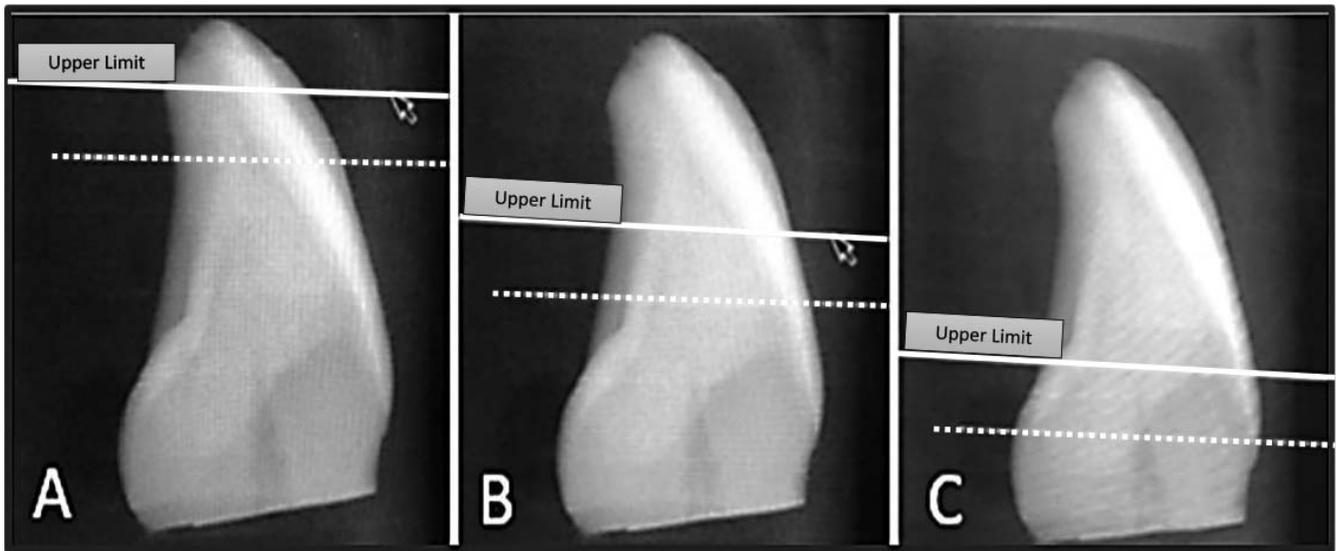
μ CT scout scan used to identify the (A) incisal, (B) middle, and (C) cervical thirds of each tooth, with upper limit of each third identified.
